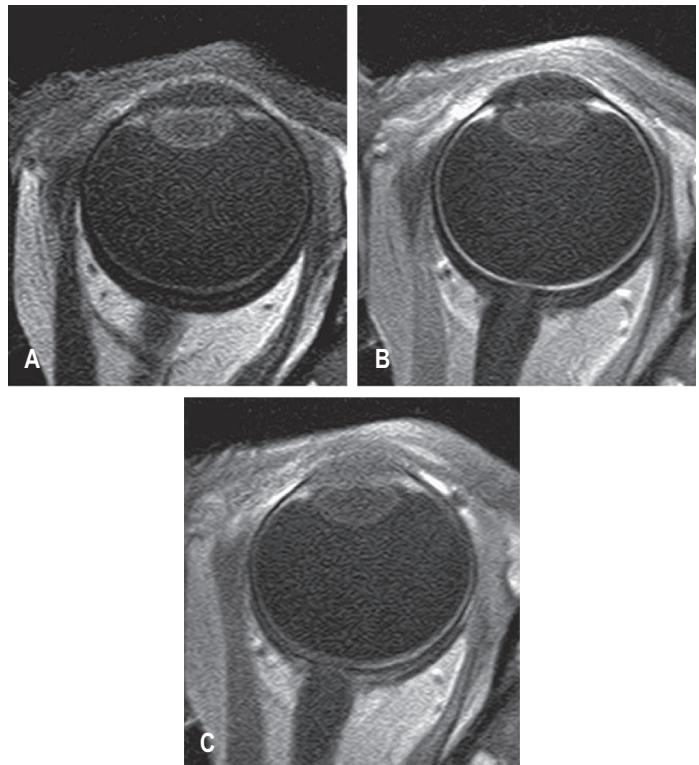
Contrast-enhanced MRI images of the eye. (A) Pre-contrast image shows details of tissues in the anterior segment of the eye, including iris, ciliary body and both the anterior and posterior chambers. (B) Within 2 minutes of contrast infusion, there is clear enhancement of the ciliary body and the choroid, but the anterior chamber, posterior chamber and vitreous body show no enhancement. (C) After 90 minutes, the enhancement in the ciliary body and choroid has begun to diminish. There is clear enhancement in the anterior chamber but the posterior chamber and the vitreous remain unchanged from A and B. (From Freddo, 2013.)
